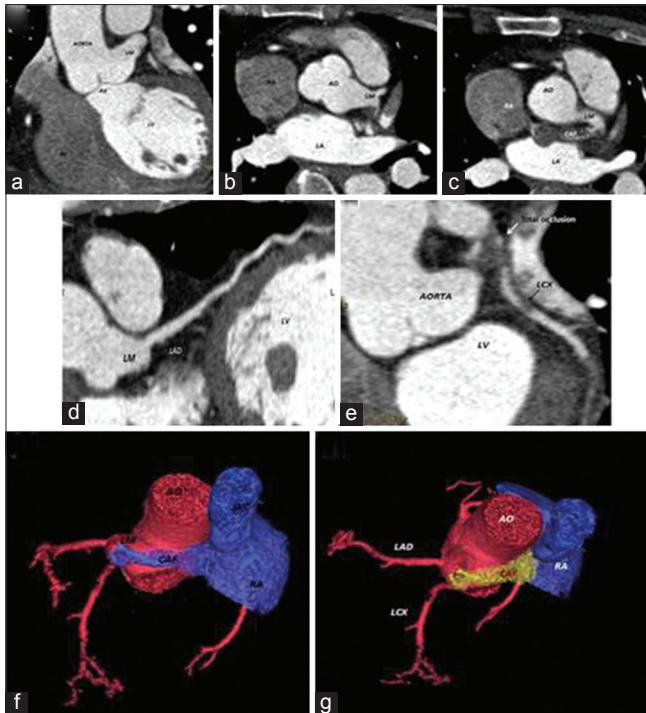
Computed tomography coronary angiography. (a) Maximum intensity projection (MIP), showing the aneurysmal dilatation of the left main (LM) coronary artery. (b) MIP image at the level of LM coronary artery and the ostium of LAD and left circumflex coronary artery (LCX) showing aneurysmal dilatation of LM and occluded LCX from its ostium. (c) multi planner reformation (MPR) image, note the thrombosed fistula between LM and right atrium (RA). (d) MPR image, showing normal left anterior descending artery. (e) MPR image, note the occluded LCX artery at the ostium (arrow) by thrombus, mid and distal thromboses. (f and g) volume rendering images showing the three dimensional orientation of the anatomy and the course of the fistula and its connections to LM and RA
